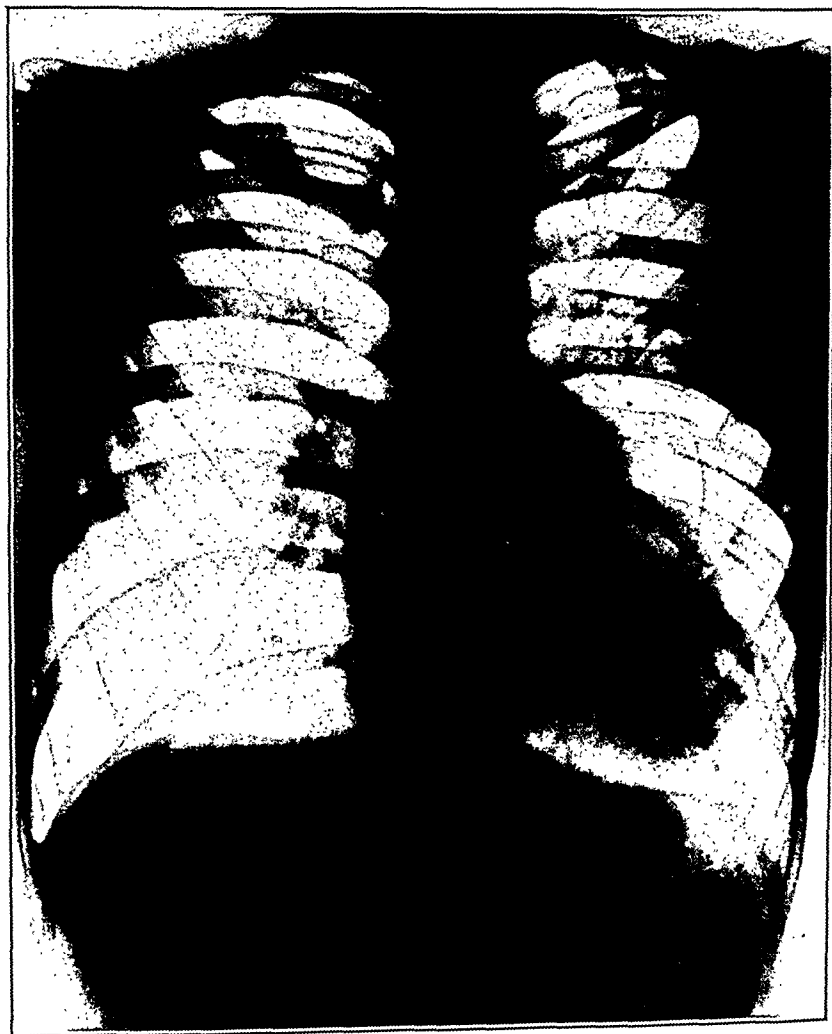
X-ray pictures of a case of pericarditis four years after operative liberation. The hernia-like protrusion of the left ventricle is very distinct.
